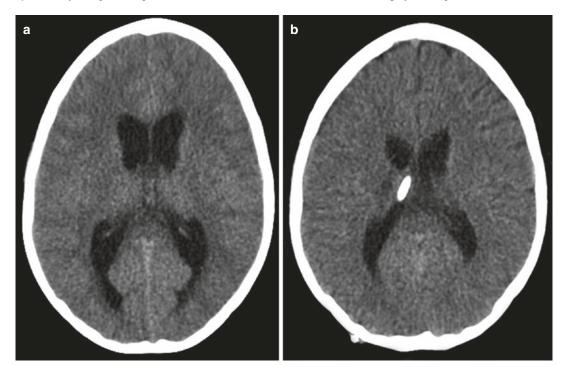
Head CT scans showing TB hydrocephalus (a) at presentation, (b) with a ventricular shunt in situ
